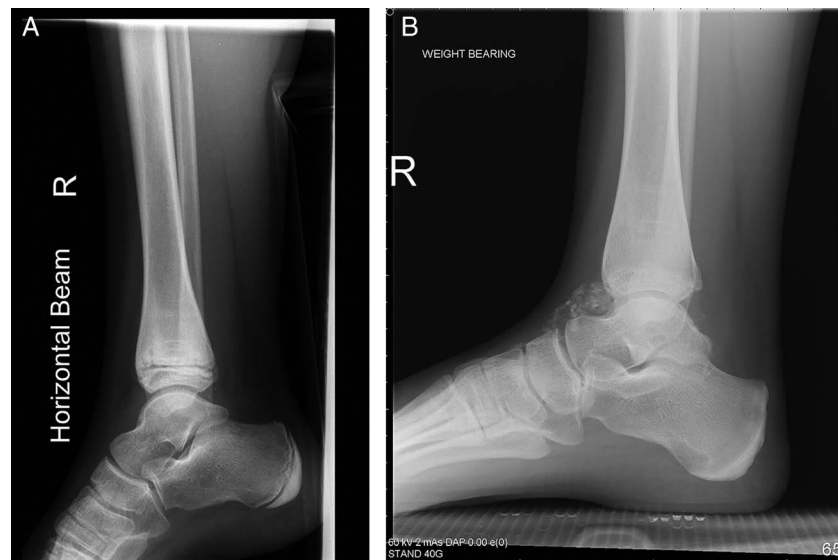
(A and B) Lateral radiographs of the right ankle preskeletal and postskeletal maturity over a 5-year interval showing development of dystrophic calcification anterior to the joint.
